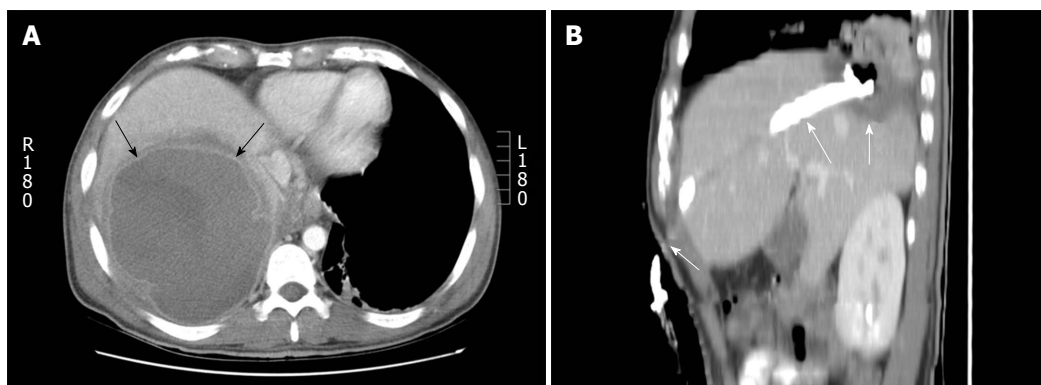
Percutaneous drainage of hepatic dome abscess in a 36-year-old man. A: Axial contrast computed tomography shows the large hepatic dome abscess (arrows). Pleural transgression carried an increased risk of pleural complications; B: Percutaneous catheter drainage using a subcostal approach (arrows) allowed successful abscess treatment while avoiding pleural transgression.
